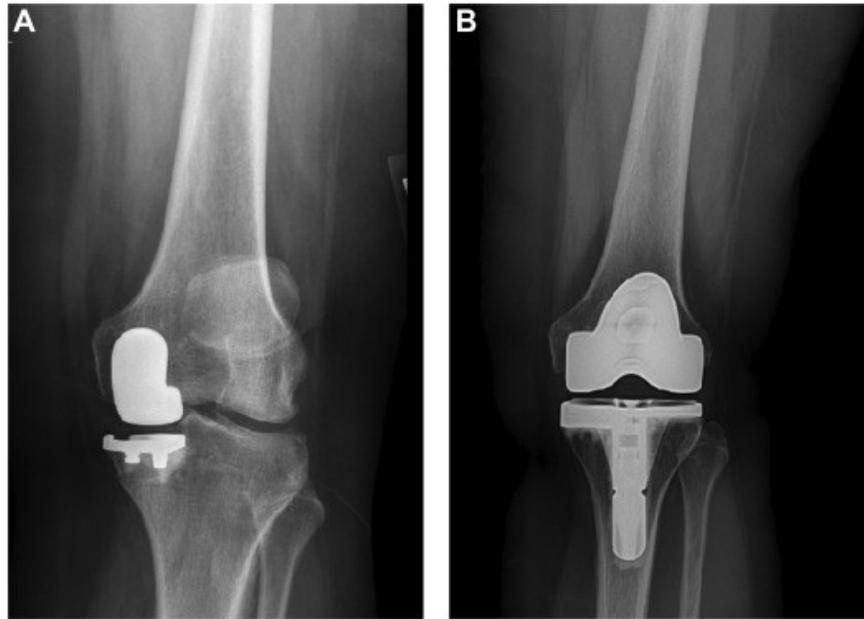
Post-operative x-ray imaging of two knee joints that have undergone partial (left) and total (right) knee arthroplasties. The prosthetic material resurfacing the articulating aspect of the joint is highlighted in white.
